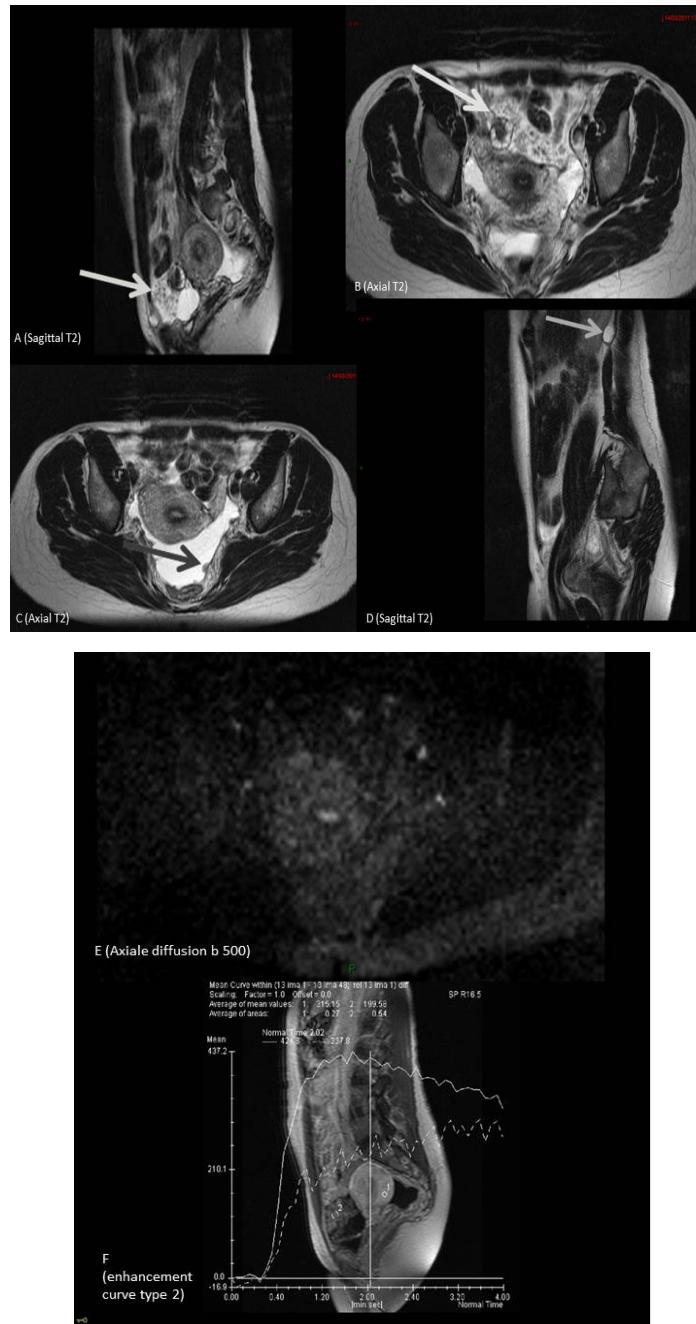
MRI images from February 2011: epithelial ovarian lesion with exophytic vegetations in sagittal and axial sections (A,B), peritoneal implants of the Pouch of Douglas (C) and an 18 mm retroperitoneal cyst behind the kidney representing a benign renal lesion (D), E (Axial diffusion b 500), F (perfusion curve type 2).
